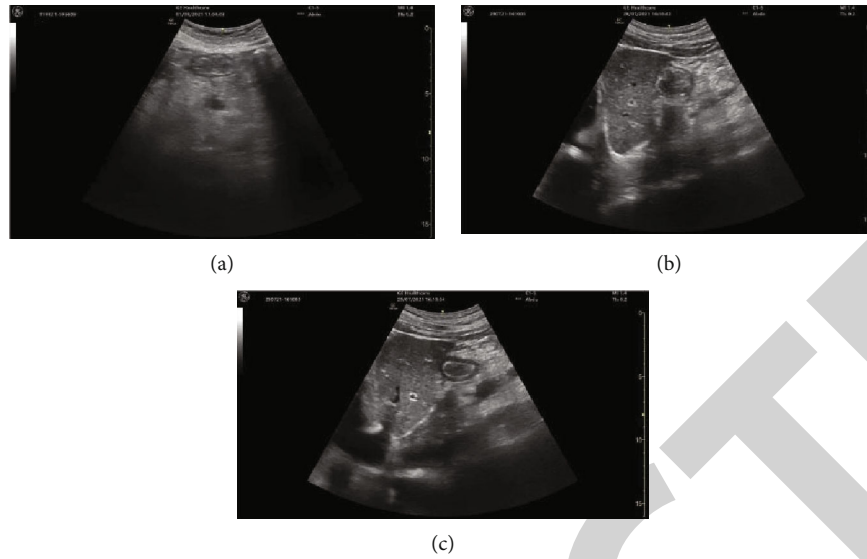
Ultrasonogram of GD at different time points. (a) Before acupuncture, result of ultrasonography indicates the increased contraction area of the gastric antrum. (b) After acupuncture for two days, result of ultrasonography indicates the decreased contraction area of the gastric antrum compared with that before acupuncture treatment. (c) After acupuncture for five days, result of ultrasonography indicates that the contraction area of the gastric antrum was decreased compared with that before acupuncture treatment and was basically restored to a normal condition.
